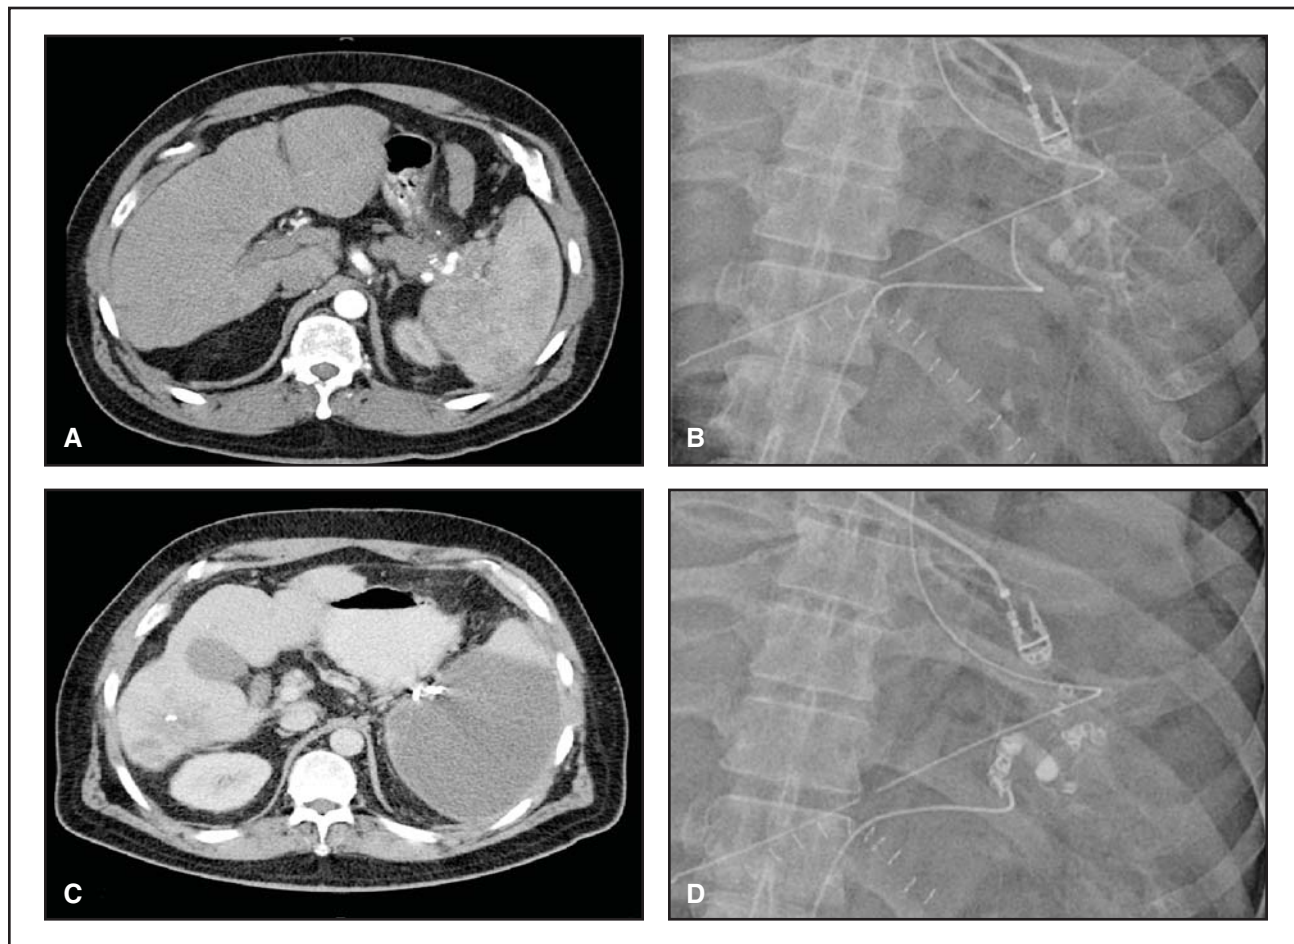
Unresectable PNET causing bleeding gastric varices. A 57-year-old man with glucagonoma and liver metastases (A-B) controlled with hepatic artery embolization presented with bleeding gastric varices. Medically unfit to endure surgery (C-D), he was treated with splenic artery embolization with complete resolution of his symptoms. Postembolization CT demonstrates nearly complete infarction of the spleen.
